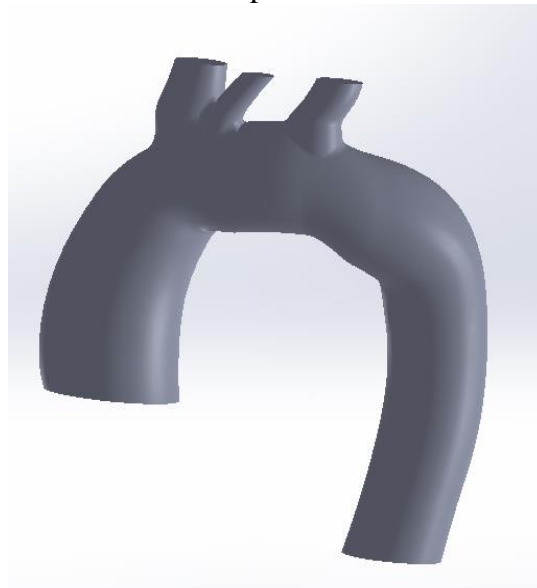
Idealized CT Aorta CAD Model
